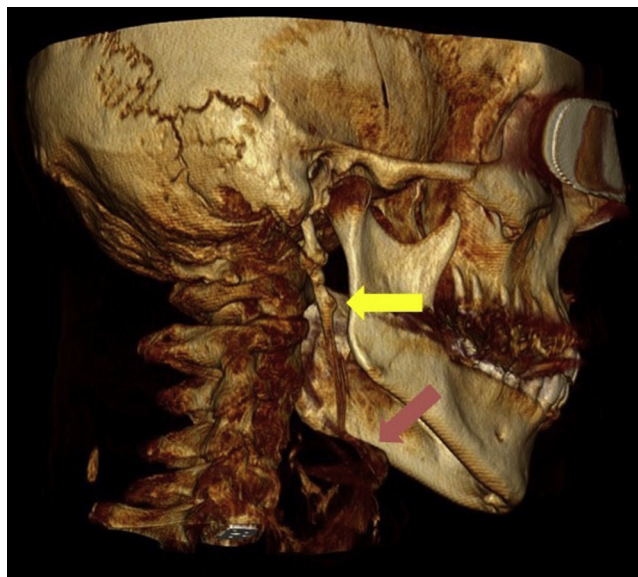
CT 3D reconstruction of the elongated styloid process on the right side: the yellow arrow points out the styloid process on the right. The red arrow is directed at the hyoid bone.
